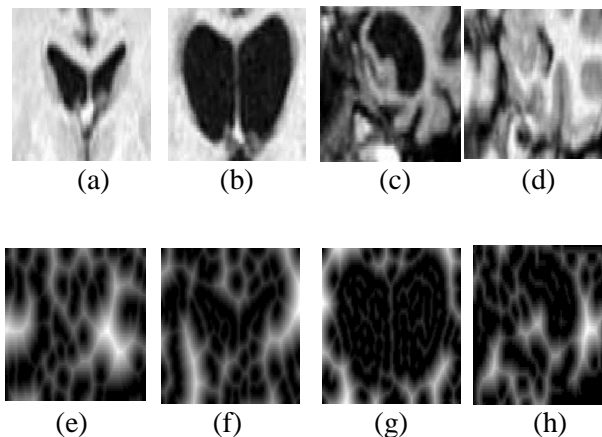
Segmented Region of Interest on Atrophied Brain MRI: (a-d) Original Brain Areas of Interest (e-h) Marked Segmented ROI
